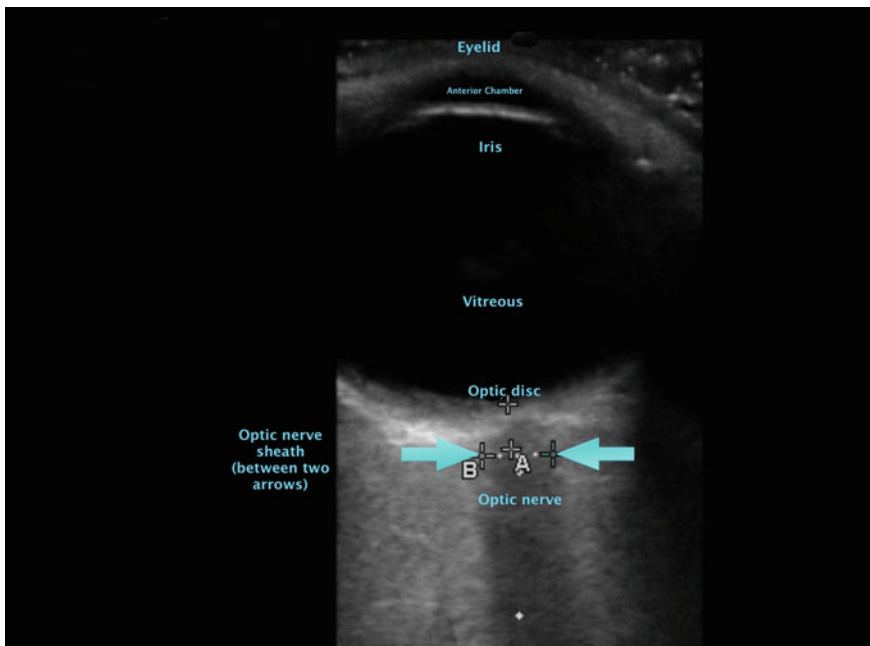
Ophthalmic ultrasound anatomy on transverse imaging
